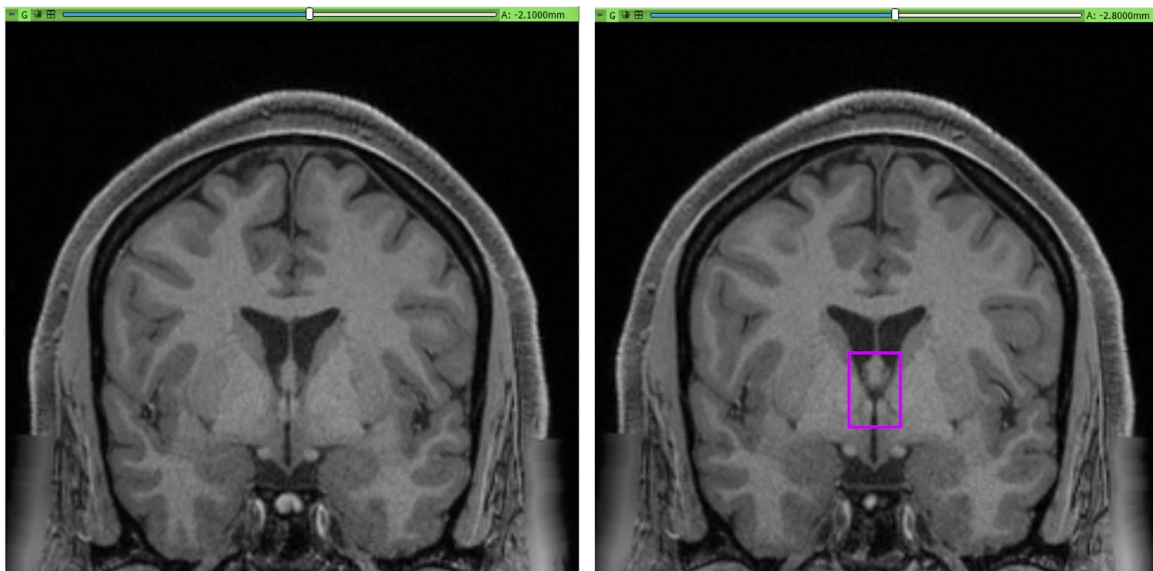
MRI image of the foramen of Monro in two sequential sections. At this level, the anterior commissure has disappeared and the fornix is divided into superior and inferior segments. The space between the two fornical segments is known as the foramen of Monro (purple box) and serves as the border between the anterior horn and the body of the lateral ventricle.
